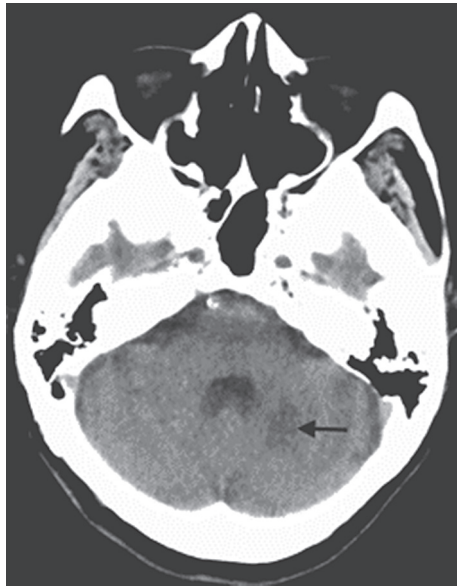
CT brain from case 1 showed infarct of the left cerebellum
